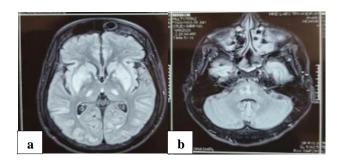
(a and b): MRI brain showing hyperintense loci in pontine and extrapontine regions.
